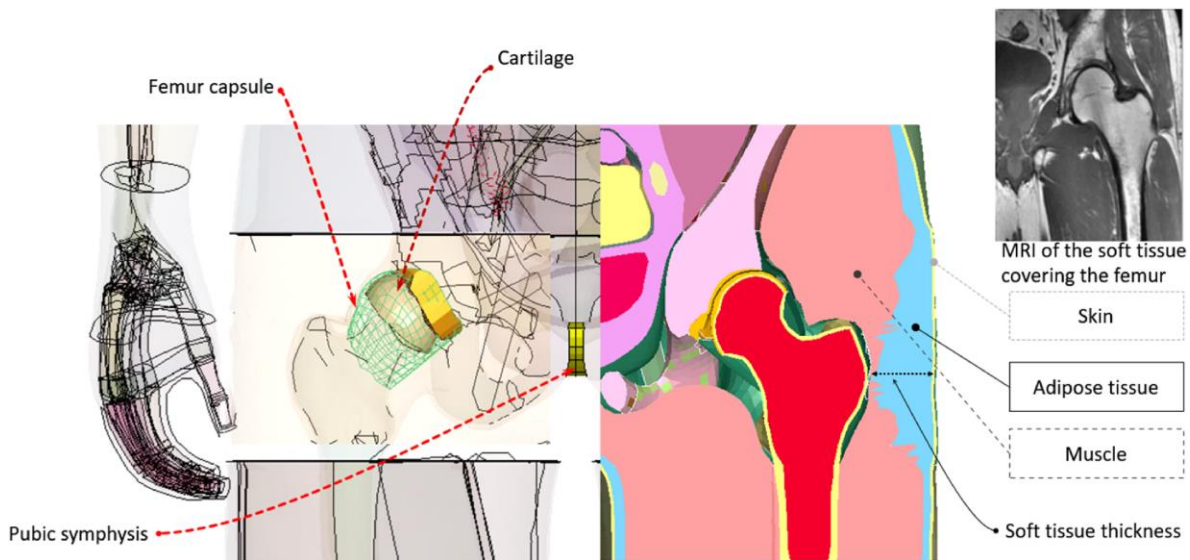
Modeled soft tissue distribution [54] of the adipose and muscle tissues over the greater trochanter using the MRI data (CC BY 4.0, The MRI image [64] has the following license agreement: CC BY-NC 3.0).
